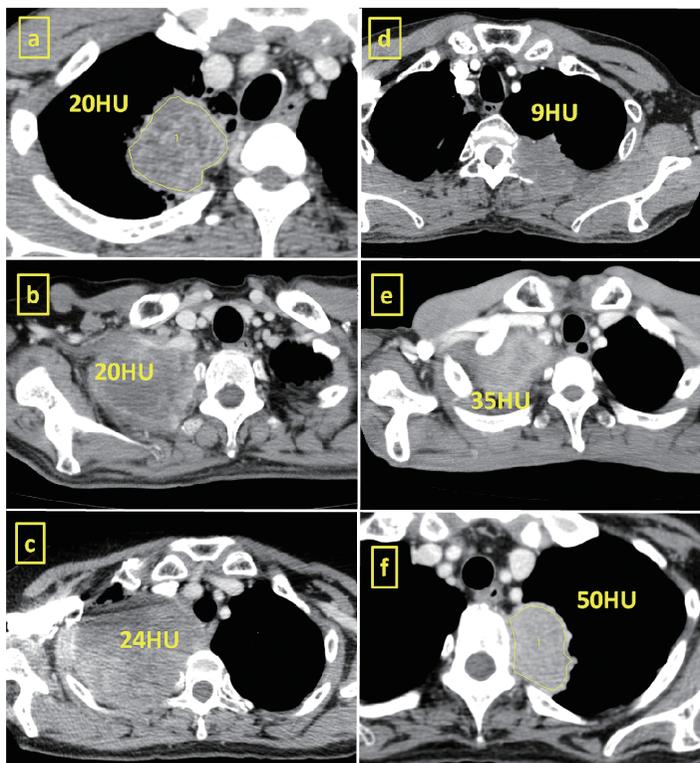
The various CT values (HU; Hounsfield Unit) of the tumors on dynamic CT, encircled by freehand. c), d), and e) show CT values obtained in the early phase of dynamic CT; a), b), and f) show values obtained in the delayed phase.
